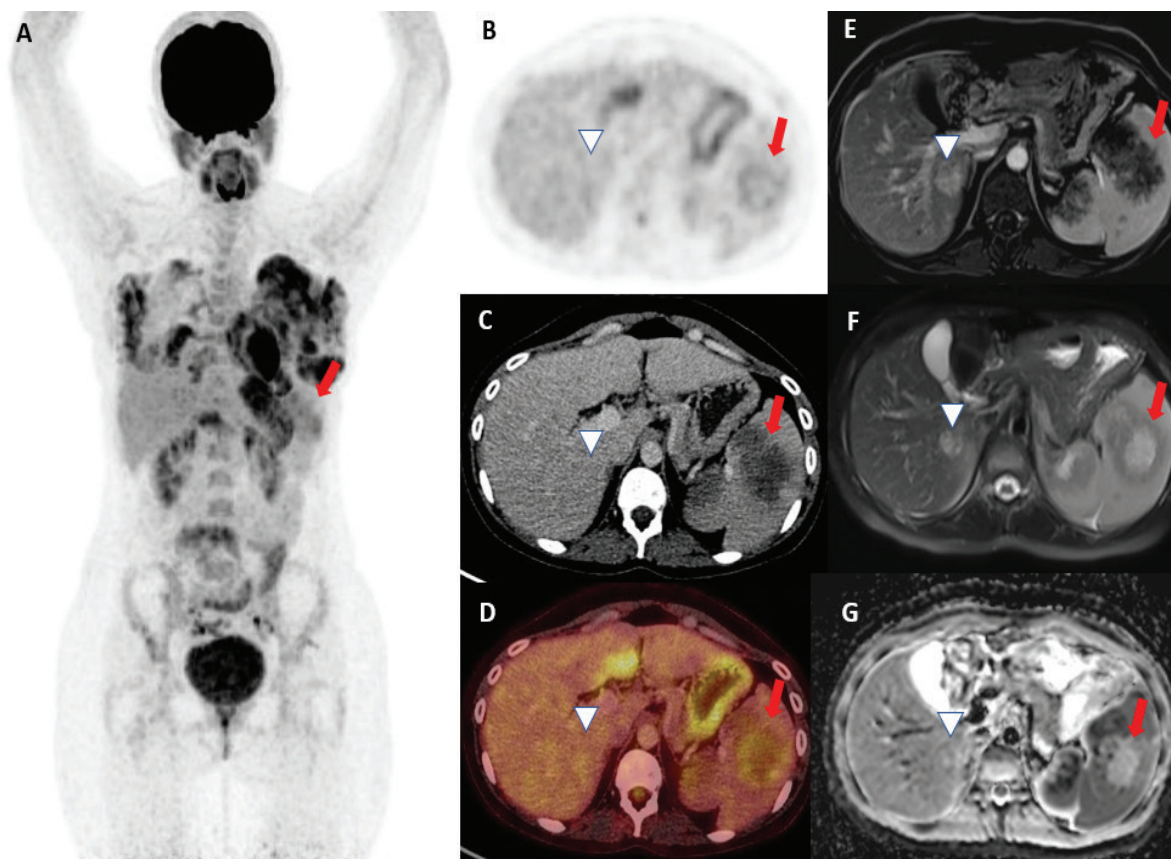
A 28-year-old breastfeeding woman presented with abdominal pain. The patient was referred with multiple spleen lesions for ¹⁸F-fluorodeoxyglucose (¹⁸F-FDG) positron emission tomography/computed tomography (PET/CT) for suspicion of lymphoma. In PET/CT images, multiple hypodense lesions were observed in spleen axial CT slices (C, arrow). These lesions showed peripheral lacy mild FDG uptake on PET and PET/CT [maximum standardized uptake value (SUV_{max}): 4.7] (A, B, D, arrow). In addition, subcapsular multiple hypodense lesions were observed in the liver in axial CT slices and showed no FDG uptake in PET and PET/CT (B, C, D, arrowhead). Multiple intensity projection images showed intense FDG uptake in the bilateral breast parenchyma due to breastfeeding. Abdominal magnetic resonance imaging (MRI) showed multiple hypointense lesions with septa and peripheral enhancement on the T1 delayed phase and hyperintense lesions on the T2 fast spin echo in the spleen (E, F, arrow). In addition, multiple lesions in the liver showed hyperintense increasing contrast enhancement on the T1 delayed phase (E, arrowhead), hyperintense on T2 fast spin-echo (F), and restricted diffusion (G, arrowhead).
